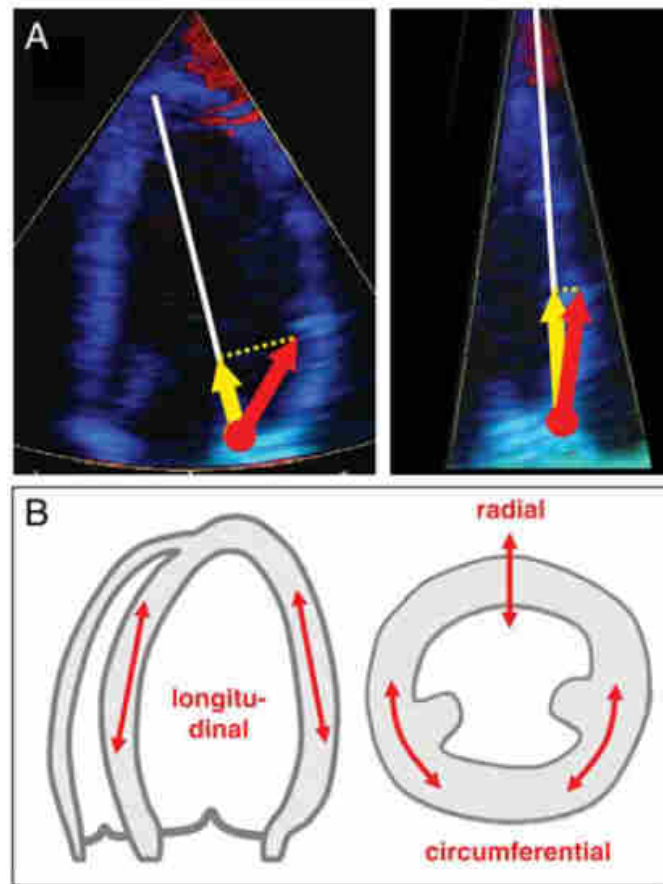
Principles for using Doppler ultrasound techniques with A showing an example of minimizing angle dependency by narrowing of the sector and B motion and deformation components that can be interrogated by Doppler (from reference [37]).
